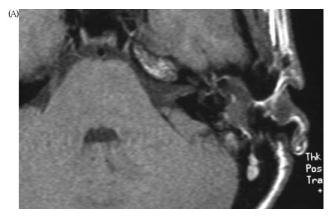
(A–E). Paragangliomas. (A) CT shows a soft tissue mass arising from the inferior mesotympanum. The adjacent lateral bony plate of the jugular canal is normal (arrows), suggesting a tympanic paraganglioma. (B) In a different patient, a similar lesion is detected at the same level. In this case, the moth eaten erosion of the bony walls of the jugular canal (arrows) is consistent with a jugulo–tympanic paraganglioma. (C and D) A larger jugulo–tympanic paraganglioma destroys the jugular spine. Through the erosion of the antero-lateral wall of the jugular foramen, the lesion invades the middle ear, encasing the ossicular chain. After contrast administration intense enhancement is observed. (E) Jugulo–tympanic paraganglioma, MR T1 after Gd-DTPA. The lesion demonstrates marked enhancement.
